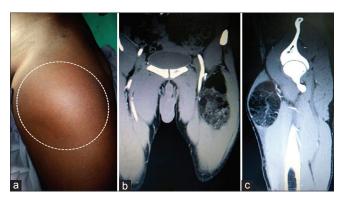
Diffuse, huge, ill-defined soft tissue swelling. (a) Contrast enhanced computed tomography scan showing a well-defined, lobulated, hypodense seen along the muscular plane of left thigh. Multiple enhancing septae noted within with no calcifications. (b and c) Anterior and lateral view
